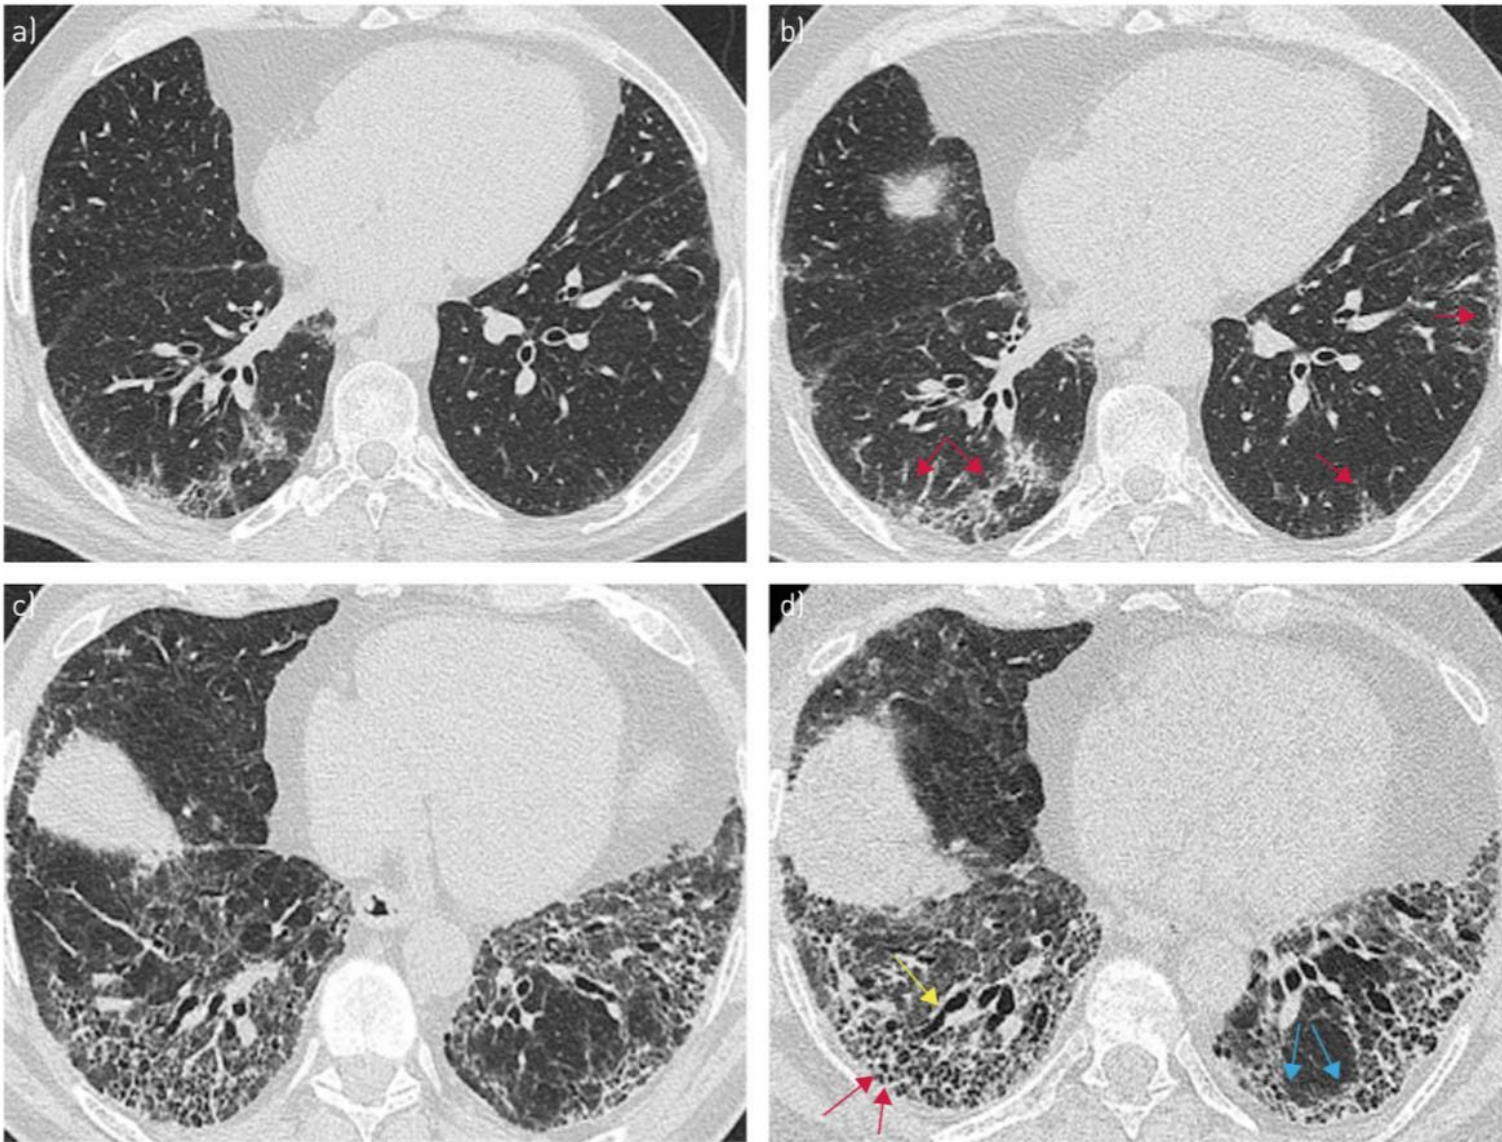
Axial computed tomography (CT) images a) at baseline and b) at a 12-month follow-up scan, in a patient with idiopathic pulmonary fibrosis (IPF). b) Note more progressive reticulation in the right lower lobe with new areas of subpleural reticulation in the left lower lobe (red arrows). Axial CT images in another patient with IPF c) at baseline and d) at a 12-month follow-up scan. d) Note the progressive honeycombing (red arrows), traction dilation of the airways (yellow arrow) and reticulation in both lobes (blue arrows).
